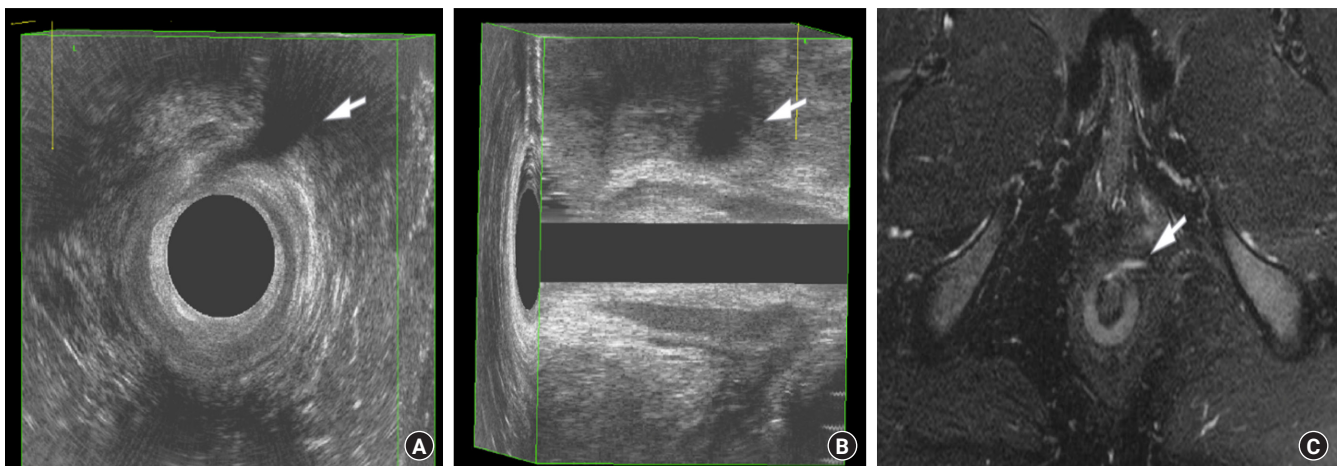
The imaging findings of a high anterior transsphincteric fistula (arrows). The 3-dimensional endoanal ultrasound images in (A) the axial plane and (B) the sagittal plane. (C) The magnetic resonance imaging T2-weighted fat-saturated high-resolution sequence in the axial plane. This fistula was categorized as grade 3A by the new classification.
